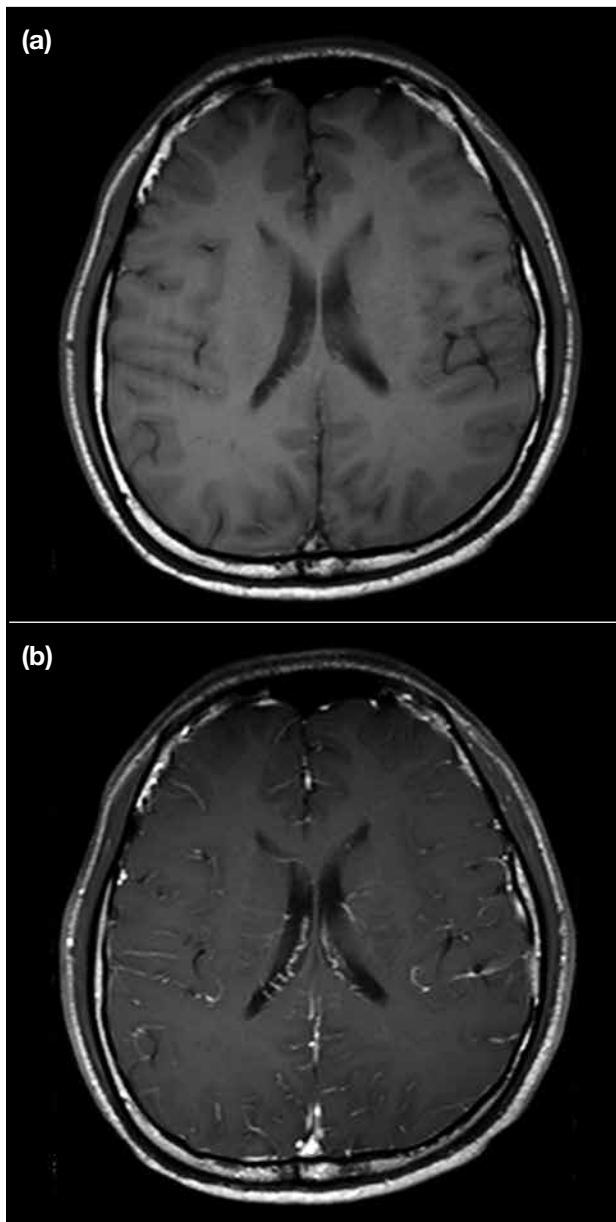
(a) T1-weighted and (b) T2-weighted post-contrast magnetic resonance images showing diffuse leptomeningeal enhancement over the brain, suggestive of meningitis.
